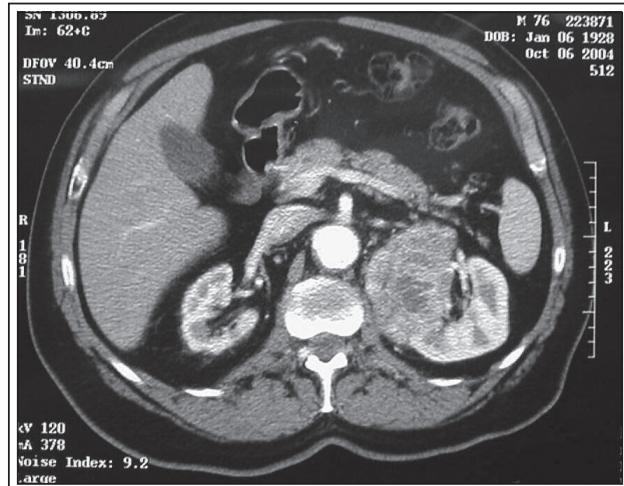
CT reveals synchronous 9 cm left renal mass.
